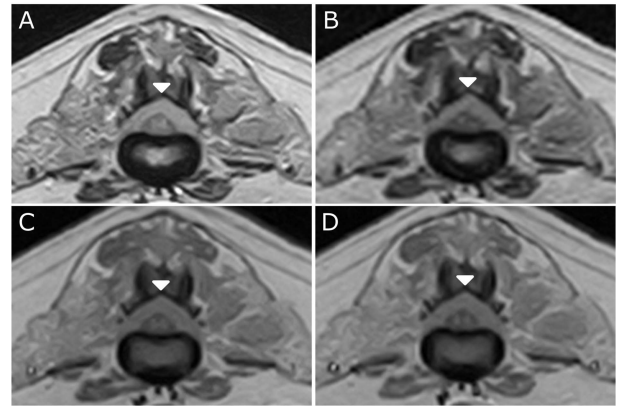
On transverse magnetic resonance images, there was a high-signal lesion (arrowhead) on T2-weighted (A), Fluid-attenuated inversion recovery (FLAIR) (B), T1-weighted (C), and contrasted T1-weighted (D) images. The lesion was well circumscribed. The spinal cord was compressed and displaced to the ventrally by the mass. No abnormal findings were noted in the muscle surrounding the L1-3 vertebra.
